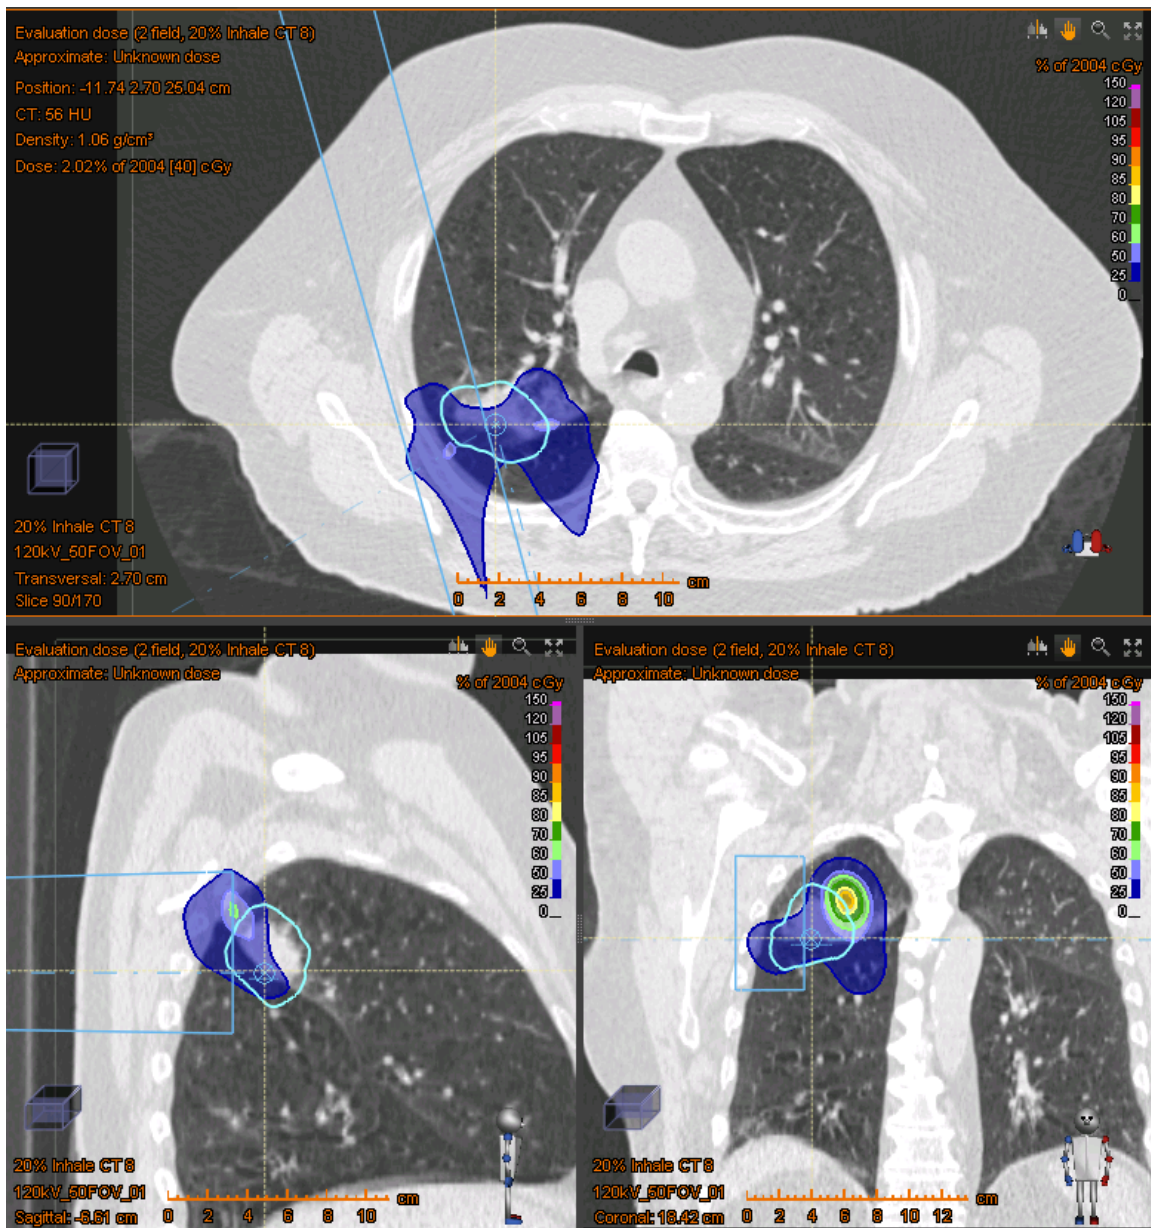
Field 1&2 – Dose delivered to 20% inhale CT phase
